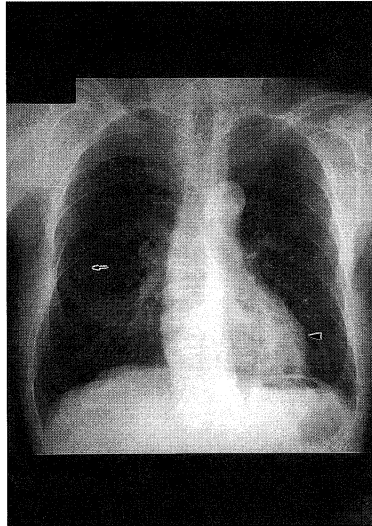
Chest roentgenogram on admission revealed a nodular-like shadow (7×5 cm) in the left lower lung field (arrowhead) and another nodular shadow (2×2 cm) in the right middle lung field (arrow).
